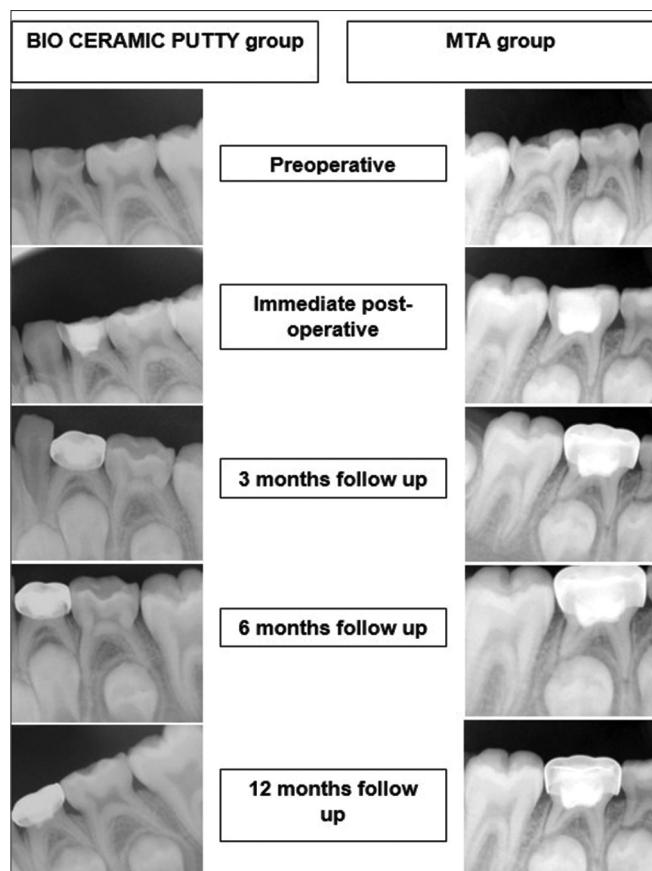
Radiographs of teeth treated with MTA and bioceramic at different time intervals.
